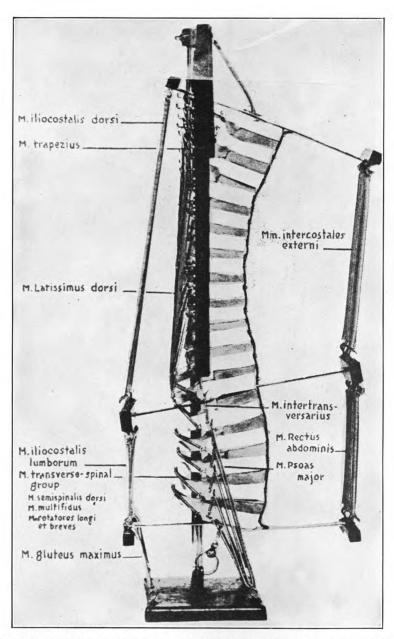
LATERAL ASPECT OF THE DYNAMIC MUSCLE-BONE BALANCE MODEL OF THE HUMAN SPINE.
